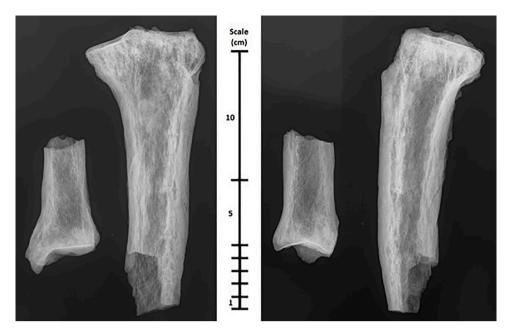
Radiographs of proximal and distal fragments of the left tibia positioned in anterior-posterior (left) and medio-lateral (right) views. Radiographic features include thickened cortex and mottled medullary cavity, strongly suggestive of Paget's disease.
